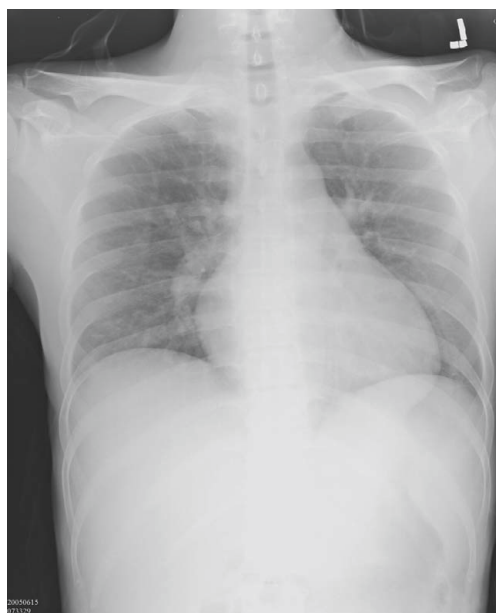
Preoperative chest radiography depicts cardiomegaly and engorged pulmonary arteries.
